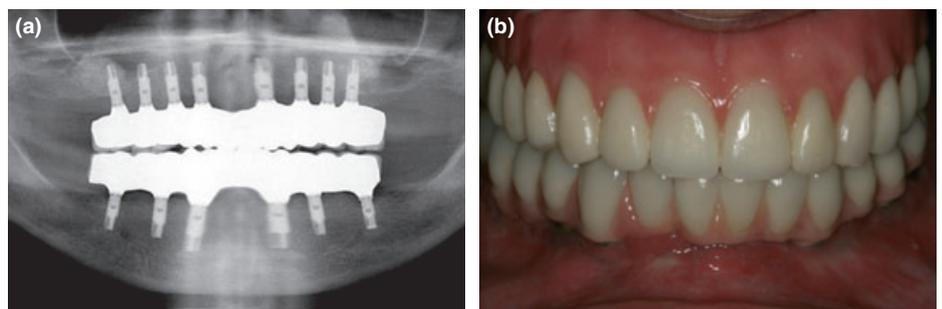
(a) and (b) Maxillary zirconia prosthesis radiographically and intraorally after 4 years of function.
